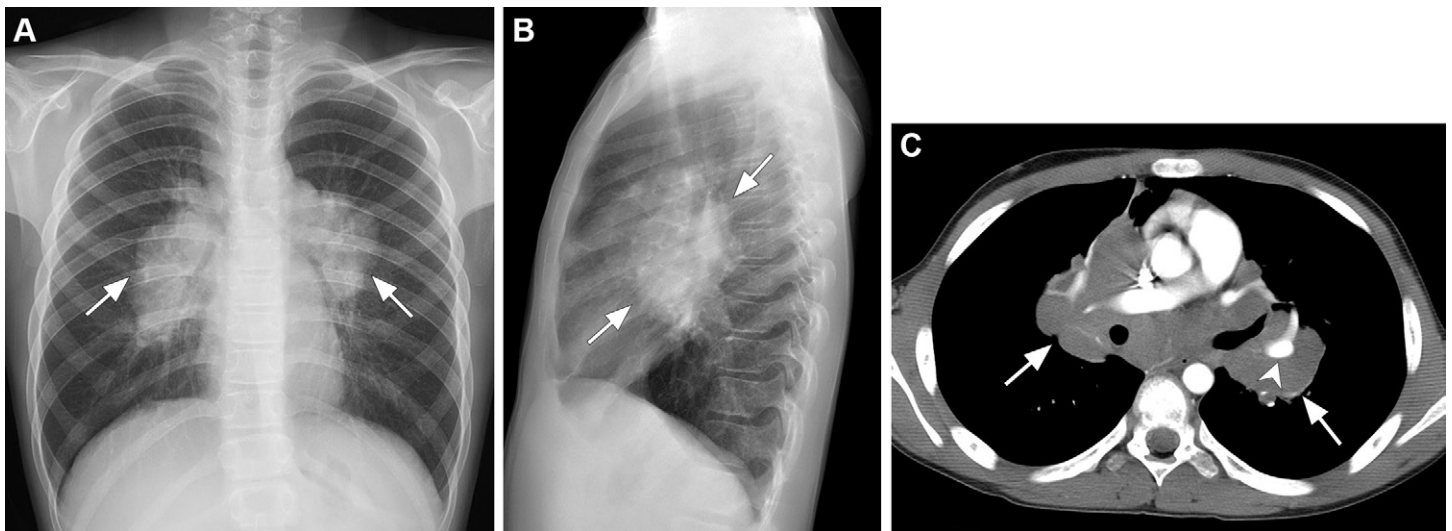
Thoracic sarcoidosis in a 12-year-old boy. (A, B) Posteroanterior (A) and lateral (B) radiographs show bilateral hilar and mediastinal lymphadenopathies (arrows) without parenchymal disease (stage 1). (C) Axial CT image (mediastinal window) confirms mediastinal and hilar lymphadenopathies (arrows), without vascular compression (arrowhead).
